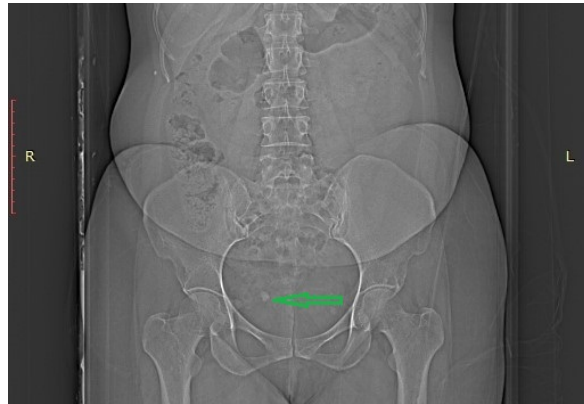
X-Ray KUB showing right lower ureteric calculus.
